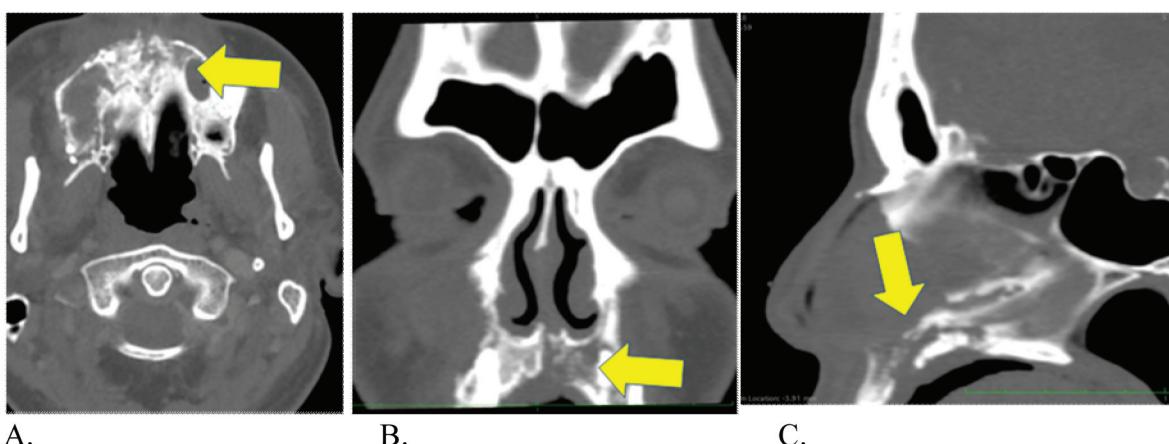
Bone infiltration by Mucormycosis. A-Axial CT shows erosion of floor of left maxillary sinus with involvement of hard palate; the erosion and destruction of hard palate can be Seen on coronal and sagittal reconstructed MDCT images (B&C)
